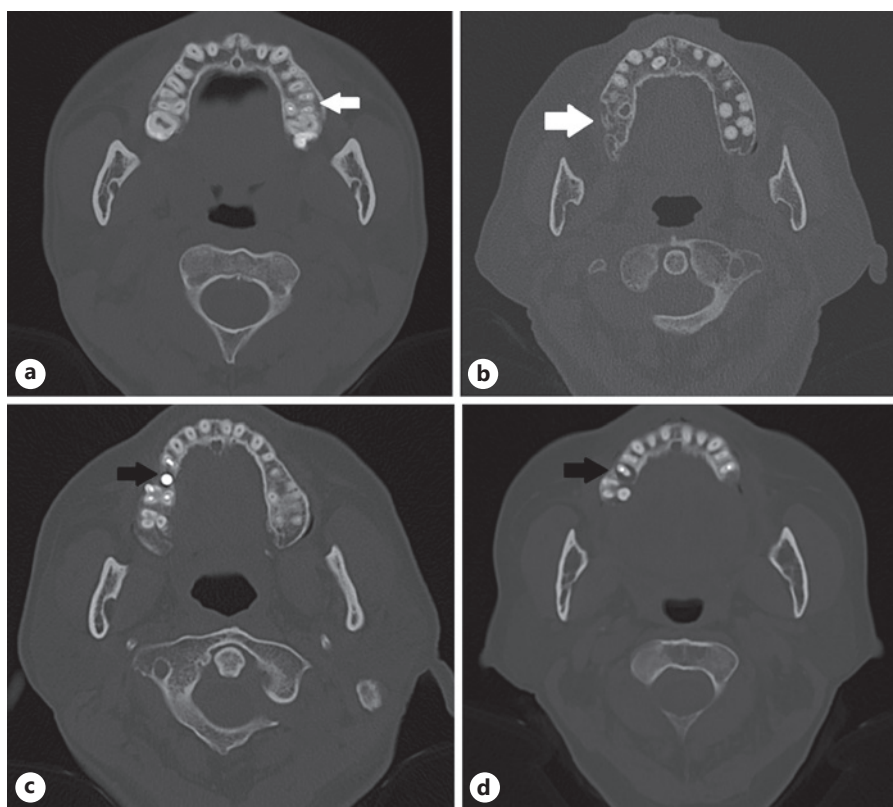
Axial computed tomography scans for examining various dental factors. a Endodontic treatment material. Note the white hyperdense spots in the roots of the left first molar (white arrow). b Tooth extraction. The first and second right molars are missing (white arrow). Adults usually have 8 teeth in each half of the upper jaw. c Dental implant (black arrow). d Apical lesion. Radiolucent opacification is evident near the root of the second premolar (black arrow).
